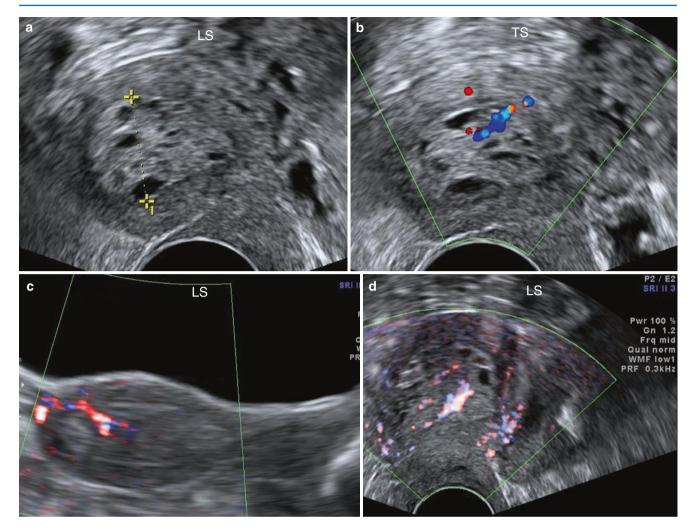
(a, b) 67-year-old postmenopausal lady with an endometrial thickness of 17.8 mm. (a) Polyp with tiny cystic spaces. (b) Feeder vessels supplying the polyp, (c, d) 70-year-old postmenopausal lady with ET of 26 mm. (c) TAS – a, single prominent feeder vessel crossing the EMJ and branching within the thickened endometrium raises a high possibility of an endometrial polyp; (d) TVS – flow seen in the endometrium in more than one vessel (PRF 0.3), but despite repeated attempts, the origin of flow across the EMJ is not seen. With TVS alone, it was not possible to see the feeder vessel from the EMJ probably because it is perpendicular to the ultrasound beam at its origin. To improve accuracy of diagnosis, doing both TAS and TVS routinely is therefore ideal
